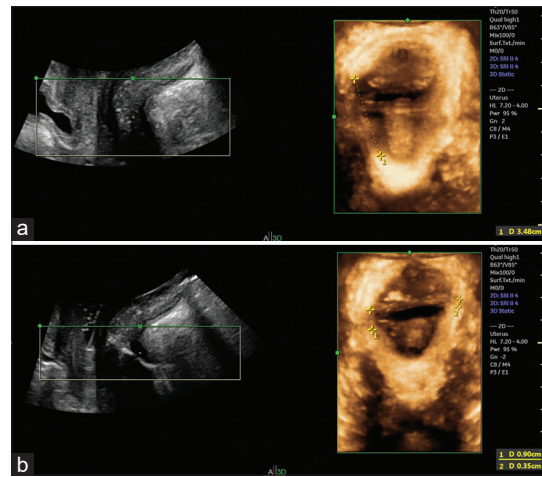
Transperineal three-dimensional ultrasound in the rendering mode showing the size of the lesion in maximum contraction of the pelvic floor before (a) and after (b) physiotherapeutic treatment
